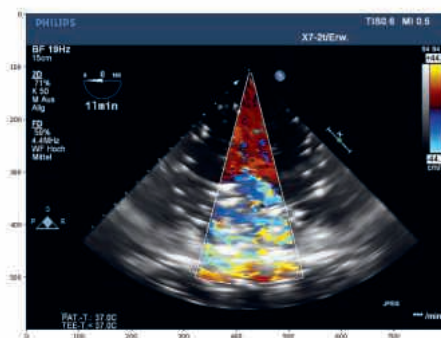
A color Doppler images used to extract the velocity
